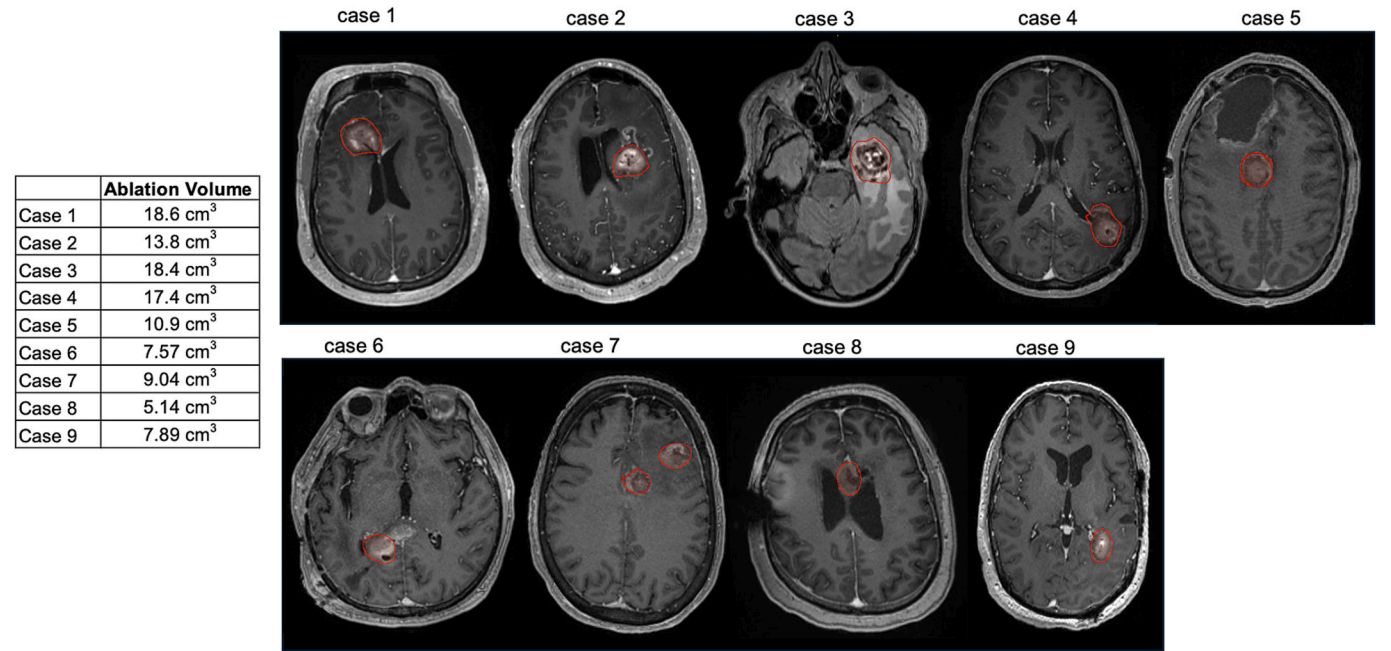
Laser ablation volumes. Representative MRI images (axial post-contrast T1-weighted MPRAGE sequences) with superimposed contour lines demonstrating the outline of the ablation volume. The table indicates the estimated thermal ablation volume for each case.
